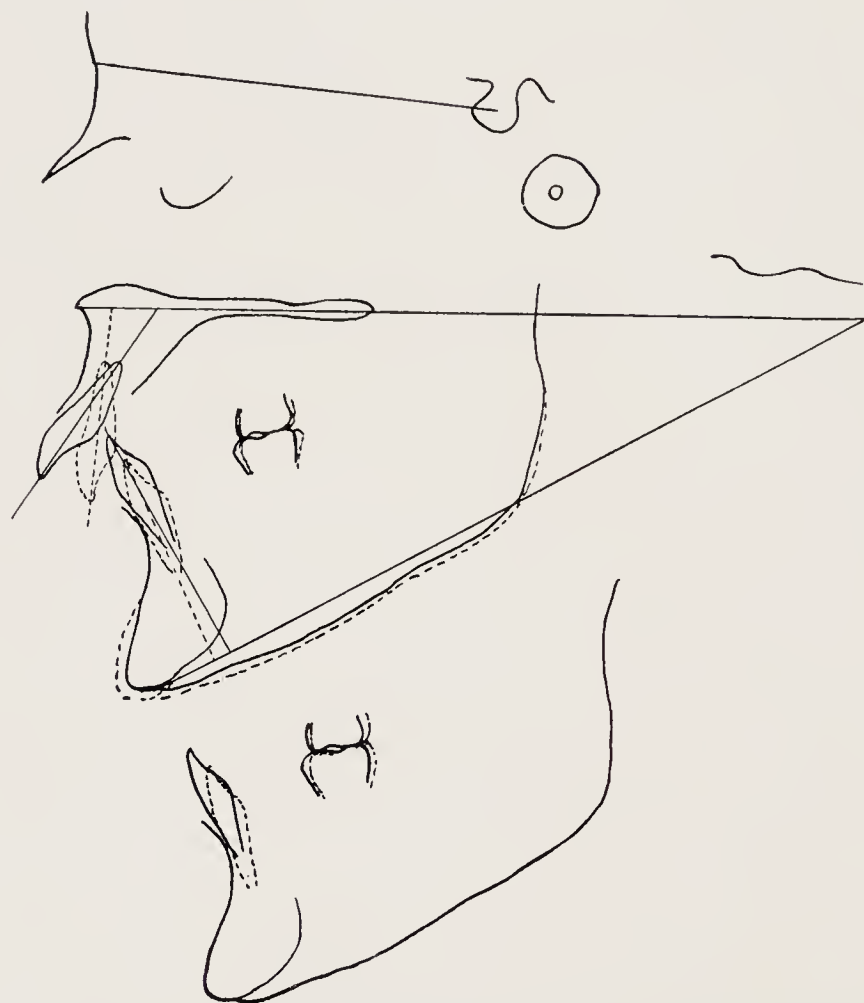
Case 4. Tracings of lateral skull radiographs, superimposed on S-N plane, and, the lower, tracings of the mandibles superimposed, showing depression of lower incisors by means of multi-banded appliances.
